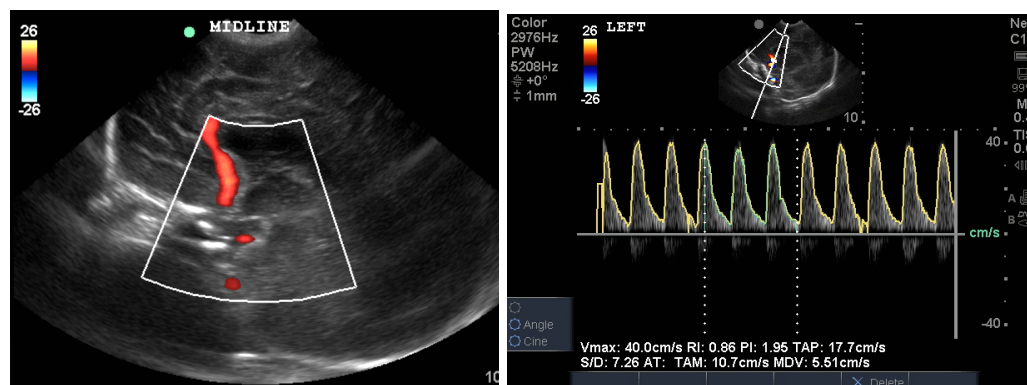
Colour image of blood flow through anterior cerebral artery from a midline sagittal image (left) and associated Doppler flow-velocity recording showing a normal Resistive Index of 0.86 (right) (Credit K Burgoine)
